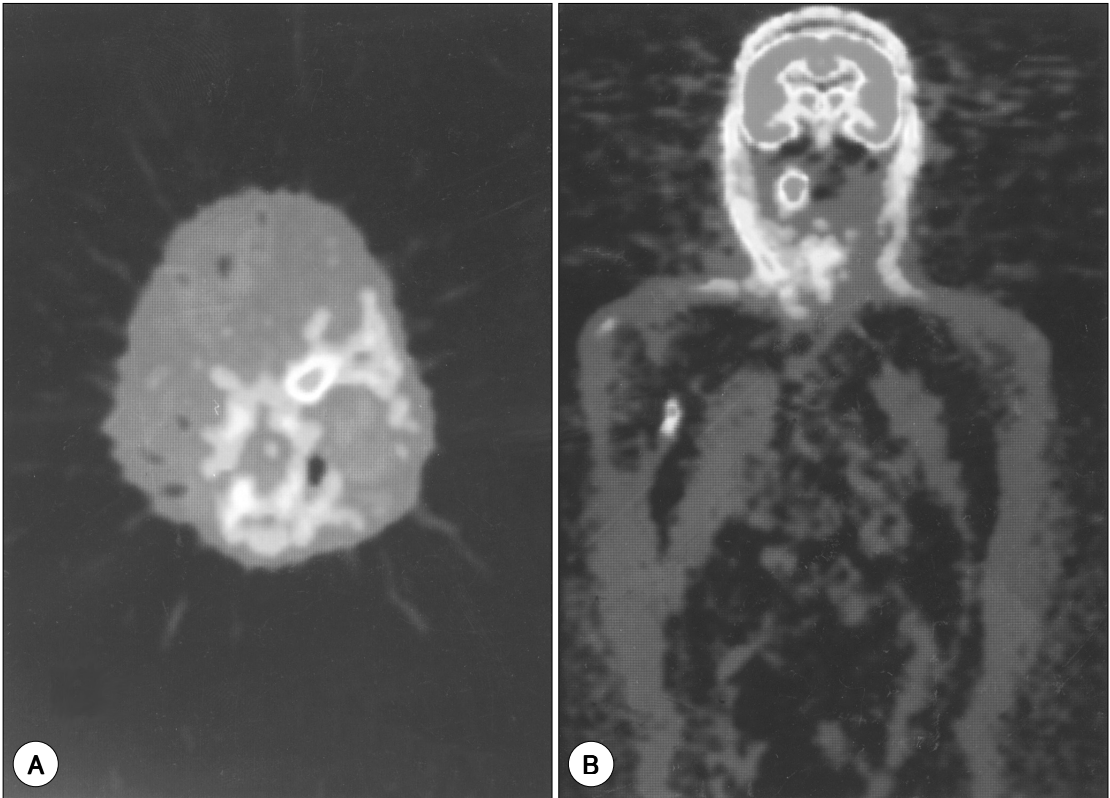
Positron emission tomography shows hot uptake of F18-FDG in the area of left internal jugular chain (A), right submandibular area and right axillary area (B).
